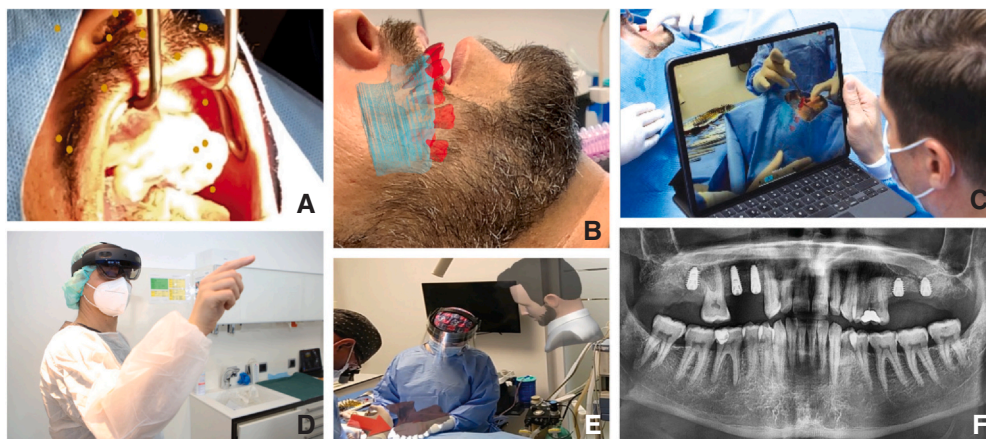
Mixed reality arrangement. A, Point of registration. B, Maxillary virtual preoperative planning model aligned to real environment with visual-inertial odometry algorithm software. C, Tablet PC see-through screen. D, Team member with head mounted display joining from remote relocation. E, Operator view (through tablet PC screen) of avatar representing team member joining from remote location. F, Radiograph 3 months after treatment.
